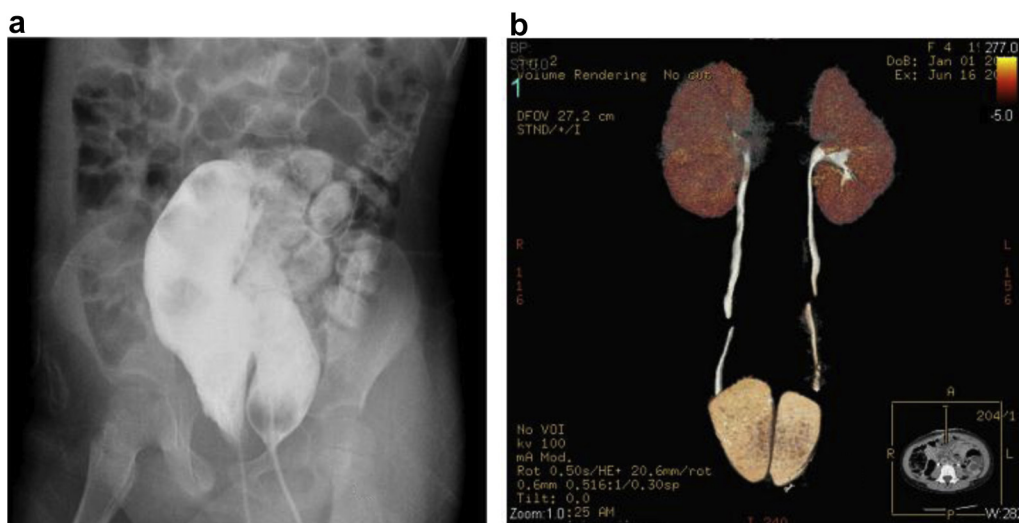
a) Preoperative contrast showing duplication, b) CT scan showing duplicated bladder and each kidney draining in to ipsilateral bladder.
